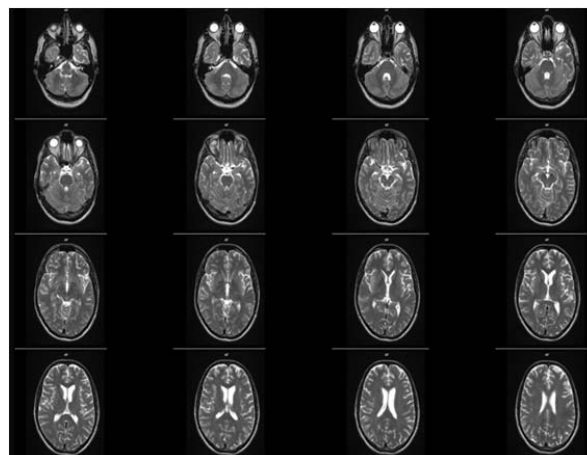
Complex MR images of brain
